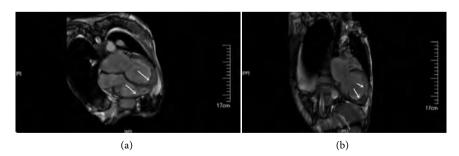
Cardiac four chamber cine MRI image demonstrated a thick non compact endocardial layer with excessive trabeculae and deep recesses (arrow) in the apical and lateral segments (a); Two chambers view showed a non-compacted hypertrabeculated spongy layer (arrows) was identified, with a ratio greater than 2.3:1 of the compacted layer at the end of diastole (b).
